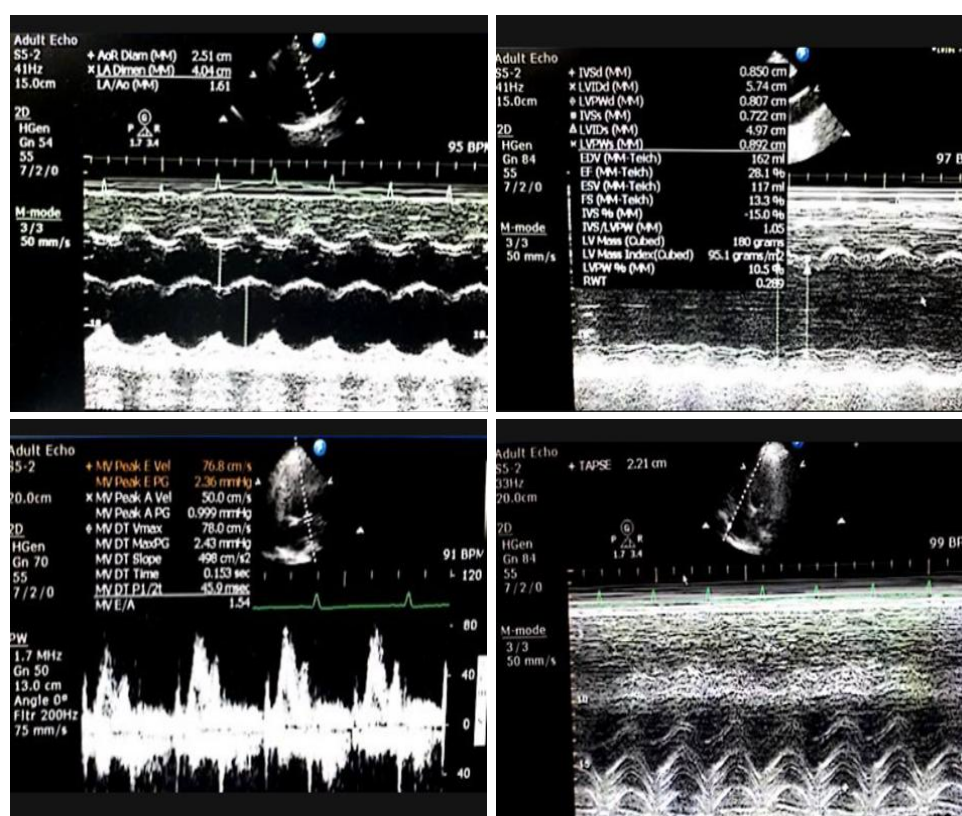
Echocardiography examination results showed left atrial and ventricular dilatation, global hypokinetic, decreased left ventricular systolic function with LVEF 28%, left ventricular diastolic dysfunction grade I with normal left atrium pressure, good RV systolic function with tricuspid annular plane systolic excursion (TAPSE) 22 mm, mild mitral valve regurgitation, no other valves either pulmonary hypertension.
